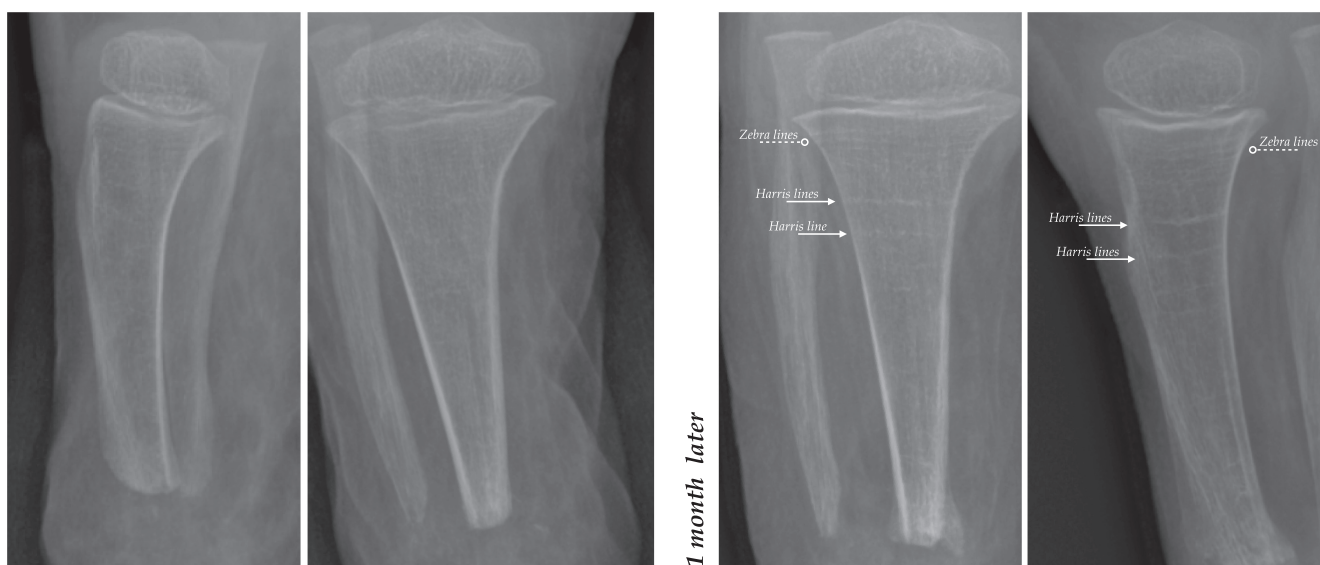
The tibia of the same individual (IT-168) was radiographed again after a one-month interval (figures on the right), and four radiopaque lesions were observed. The wavy orientation and the expansion over the half of the diameter of the two lesions located in proximity of the growth plate are consistent with the morphology of the zebra lines. The characteristics of the other two lesions (e.g., transverse orientation, expansion over the 25% of the diameter) is compatible with Harris lines.
